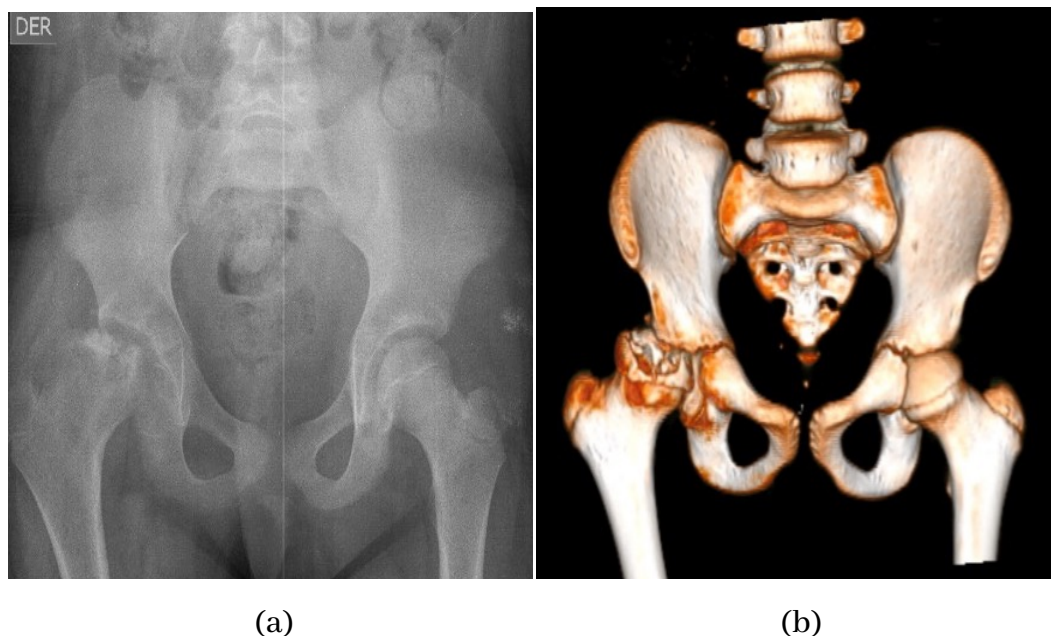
Complementary imaging studies (a) Comparative AP and axial hip X-ray: Hypoplasia and erosion of the right femoral head with dislocation of the femoroacetabular joint are observed ; (b) Computed axial tomography of the hip with 3D reconstruction: Decreased contour of the right femoral head.
